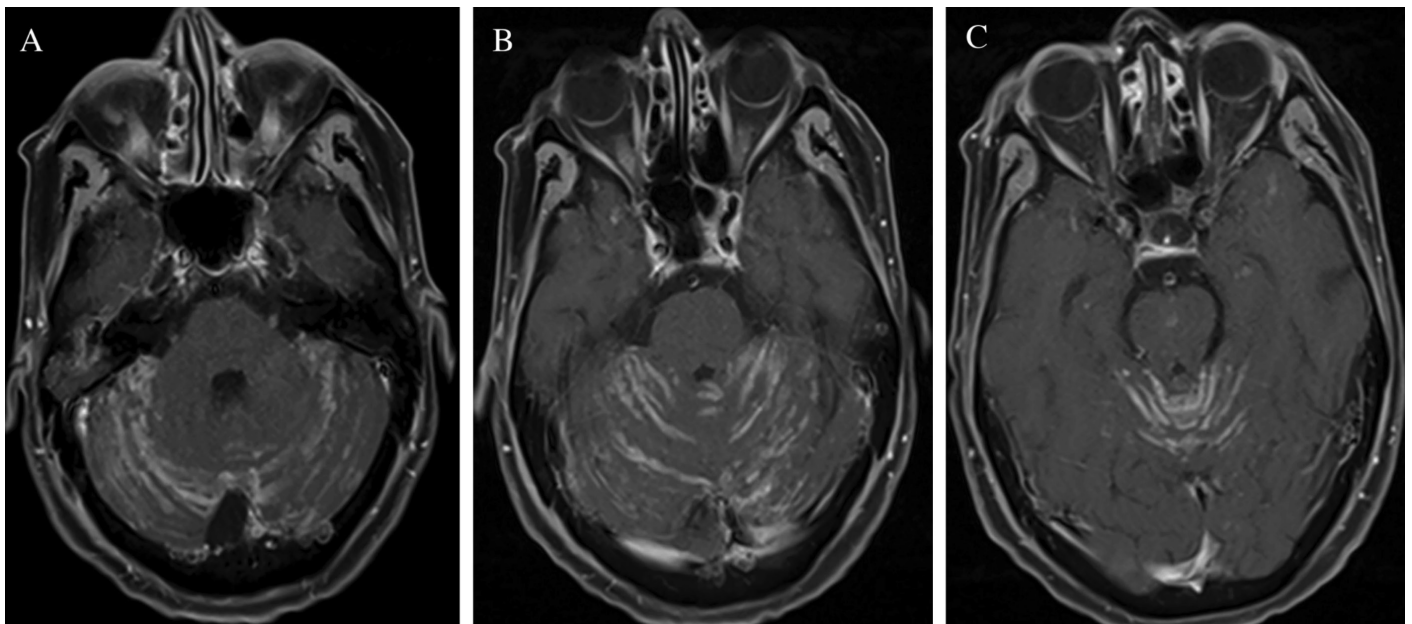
A, B, C) Post-contrast axial T1-weighted brain magnetic resonance imaging shows significant contrast enhancement in the tentorium
